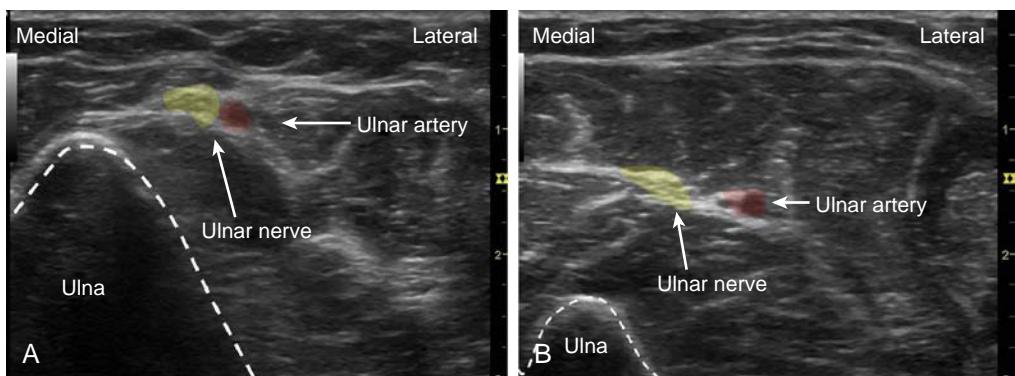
Ultrasound view of ulnar nerve at the wrist (A) and at midforearm level (B).
